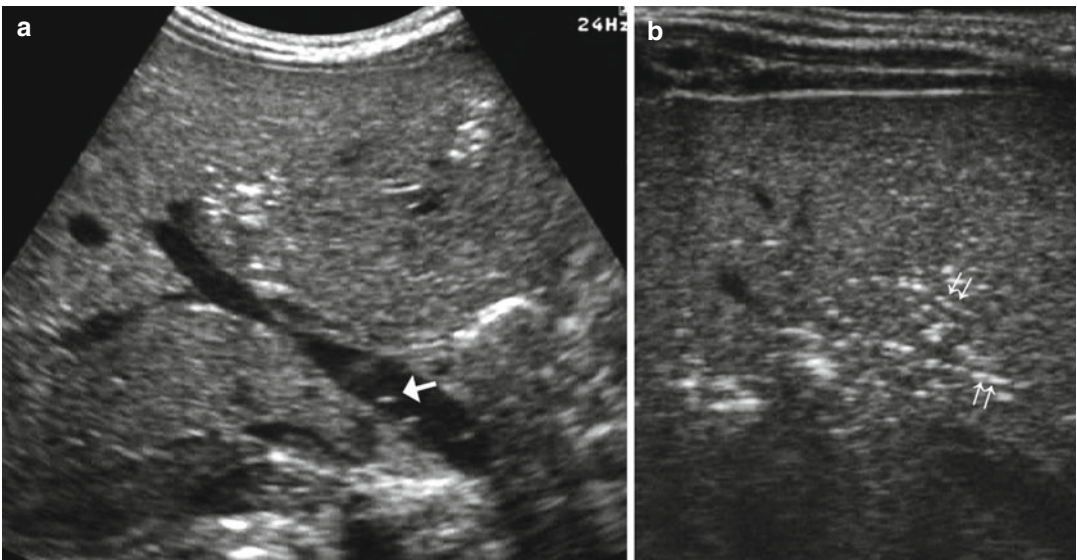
Ultrasound in newborn with NEC. (a) Portal venous gas which appears as punctate and linear, branching areas of echogenicity in the main portal vein (*white*
